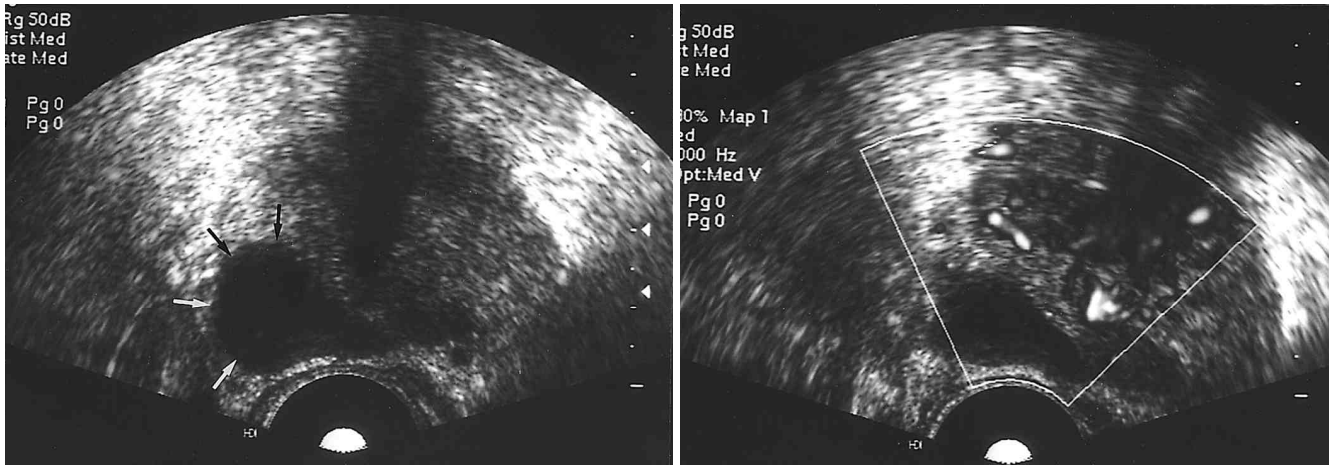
A. Axial transrectal sonogram demonstrates a well defined hypoechoic lesion in the peripheral gland with contour bulging (arrow).
